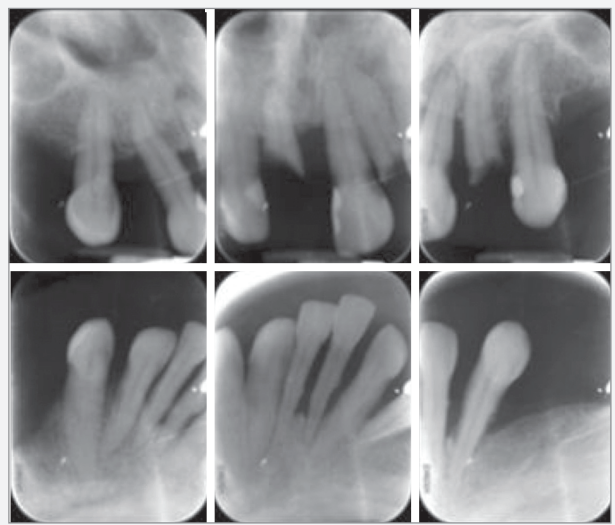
Intraoral periapical radiographs showing generalized horizontal bone loss.
